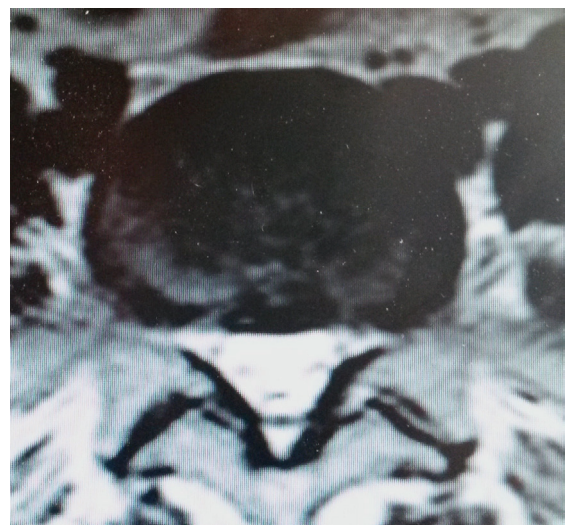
Axial T2-weighted MRI showed signs of complete regression of the herniated nucleus pulposus (the patient's third month control axial sign)
